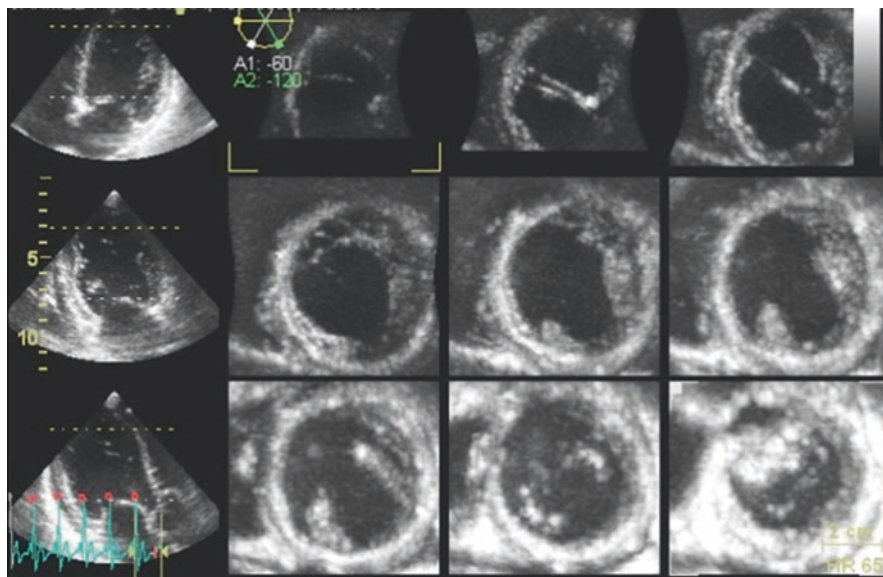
3D echocardiography (3DE) in myocarditis. 3DE tomographic representation of a dilated, remodelled, and trabeculated LV in a patient with active lymphocytic myocarditis, troponin release, and heart failure presentation. The different slices are obtained cutting the left ventricle across multiple parallel short axis planes from apex to base. This specific view is particularly useful to assess regional wall motion abnormalities
